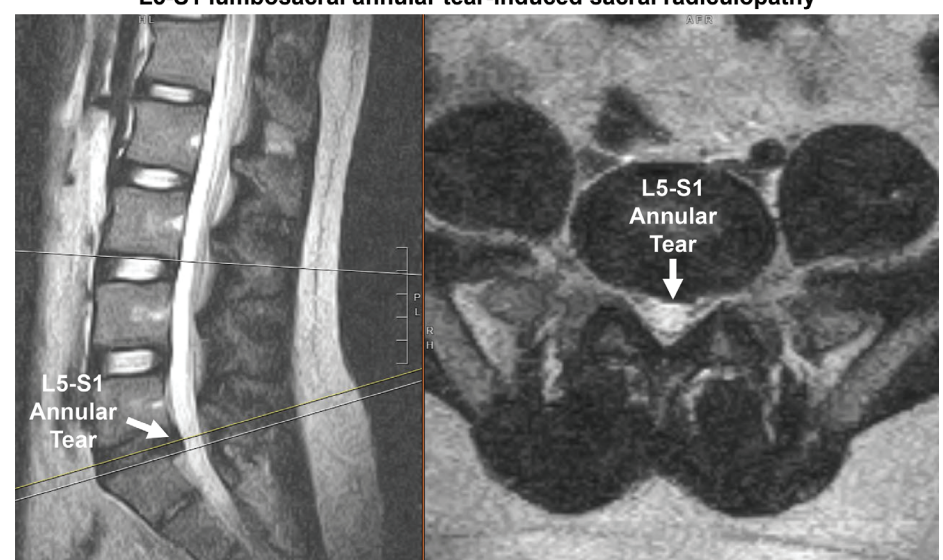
A patient with hard flaccid syndrome was suspected of having sacral radiculopathy triggered region 3 based on neurogenital testing and regional anesthesia testing. This lumbar MRI revealed an L5-S1 disc protrusion with annular tear.
